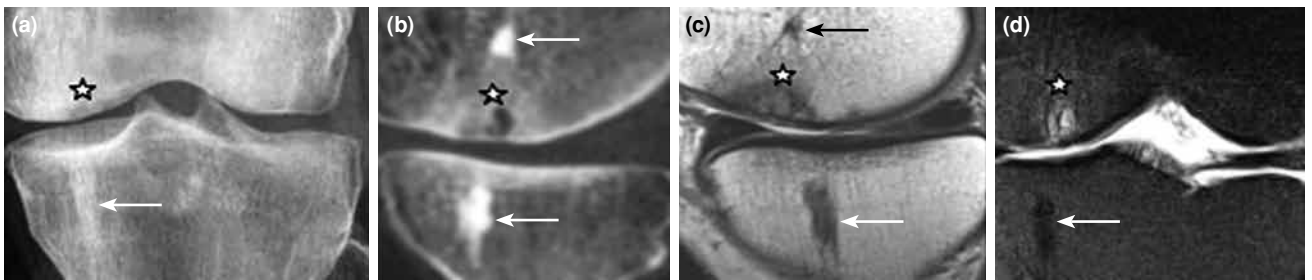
Anteroposterior radiograph of the left knee (a) shows a focal radiolucent area (star) in the medial femoral condyle which is suspicious for osteochondral lesion. There is also a sclerotic, ovoid intramedullary lesion (arrow) in the medial proximal tibial subchondral region consistent with dense a bone island. Computed tomography scan (b), T₁-weighted (c), and fat-suppressed T₂-weighted coronal (d) MR images reveal the sclerotic bone islands (arrows) on both sides of the medial knee joint, and the osteochondral lesion (star) which is “sandwiched” between these lesions.
